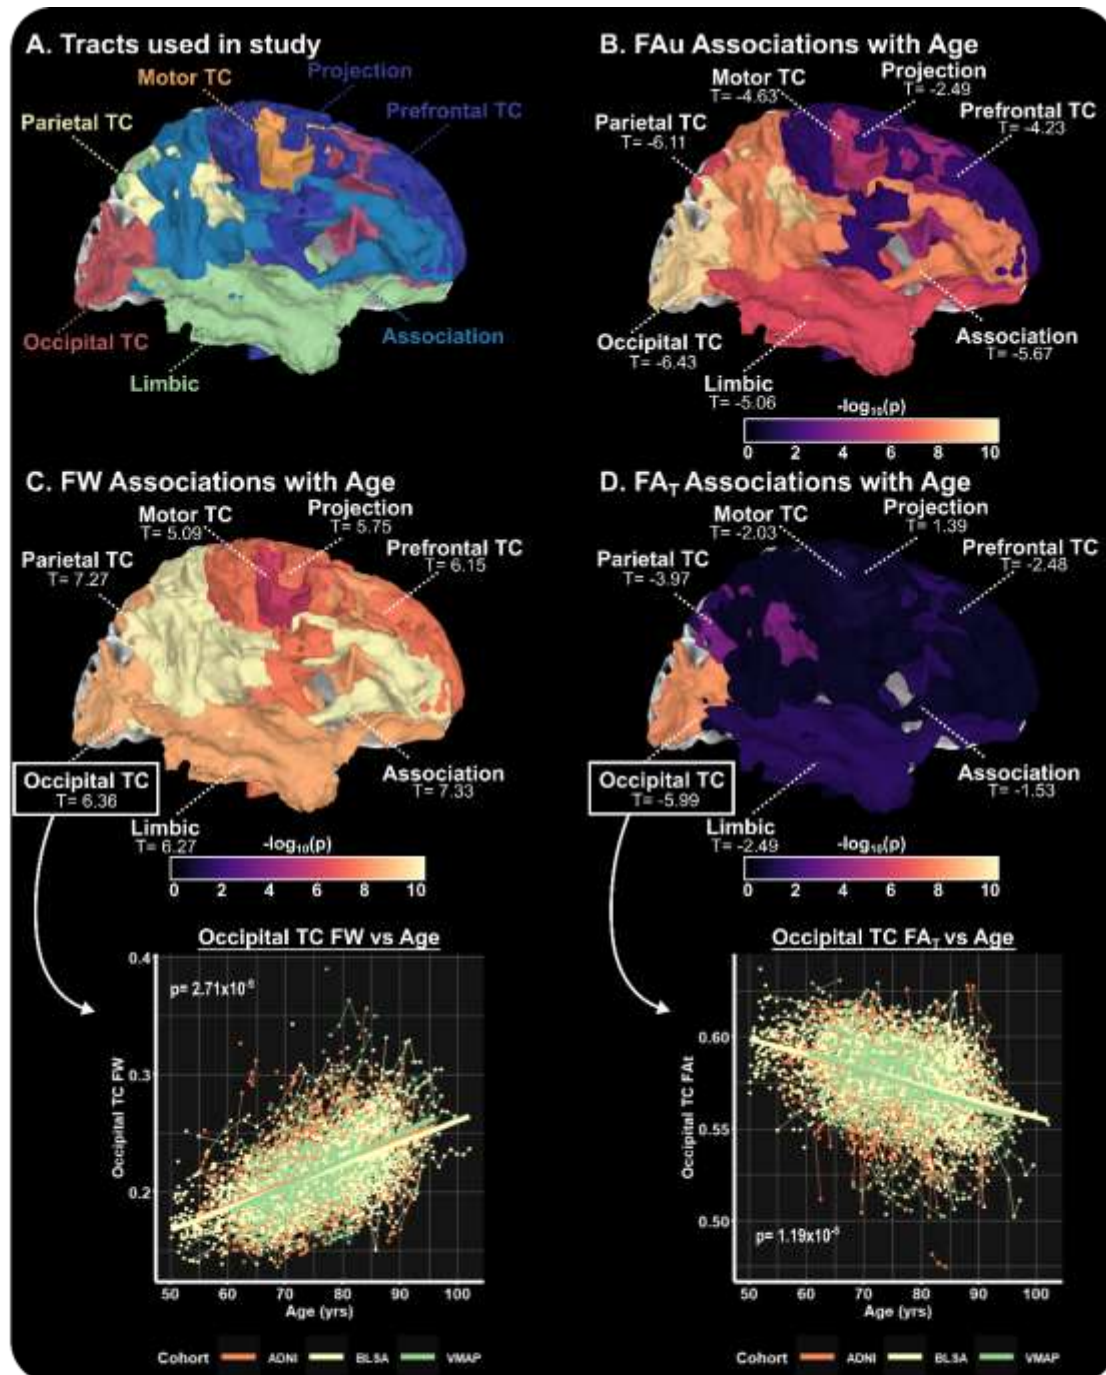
Using several white matter templates (A), this study used conventional diffusion MRI analysis to find that uncorrected fractional anisotropy (FA_u) is strongly associated with age [significant tracts ($p_{FDR} < 0.05$) labelled, B]. Leveraging free-water (FW) analysis in the same cohort, this study found that while there are global associations with FW [significant tracts ($p_{FDR} < 0.05$) labelled, C], there are tract-specific associations with FW-corrected FA (FA_T) [significant tracts ($p_{FDR} < 0.05$) labelled, D]. As an example, occipital transcallosal (TC) FW and FA_T associations with age are shown for each cohort used in this study.
